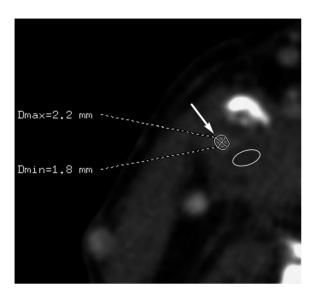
Axial image of CT angiography showing a carotid plaque. The regions of interest (white oval) in the plaque are selected widely as possible. A white arrow shows the vascular lumen.
